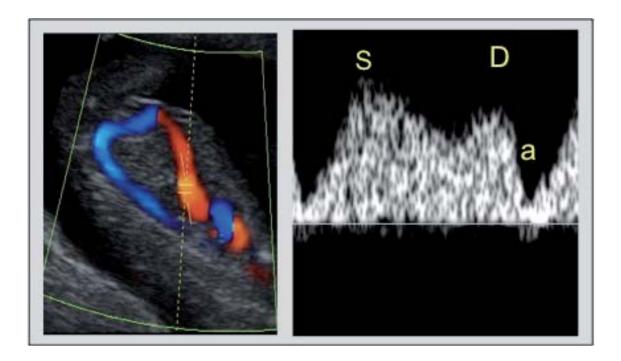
Ductus venosus color Doppler (left) and ductus venosus waveform (right) showing the three fases: (S) systole, (D) diastole, and (a) atrial contraction.
